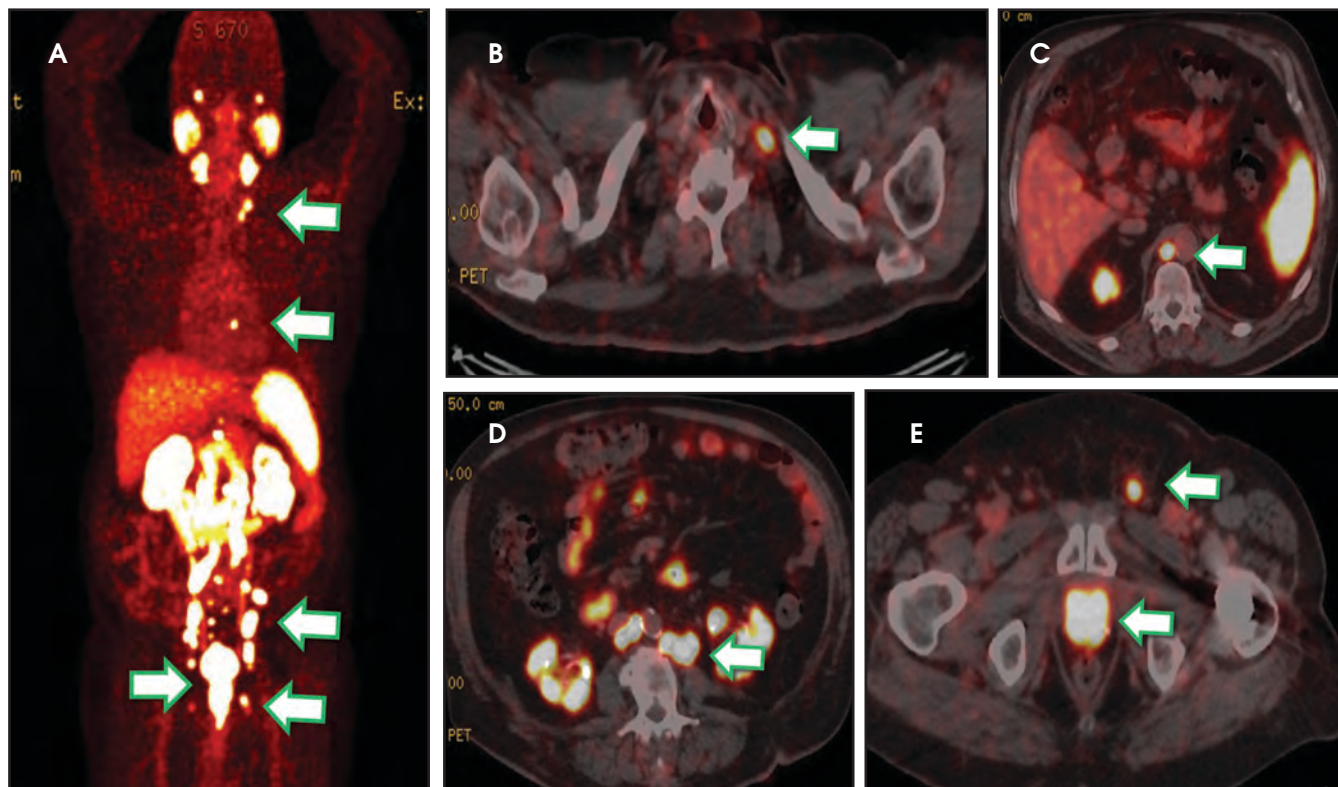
Coronal PSMA PET and fused PSMA PET/CT images demonstrate PSMA avid lymph nodes in the left supraclavicular, mediastinal, and retroperitoneal regions as well as intense uptake within the prostate gland (arrows).
